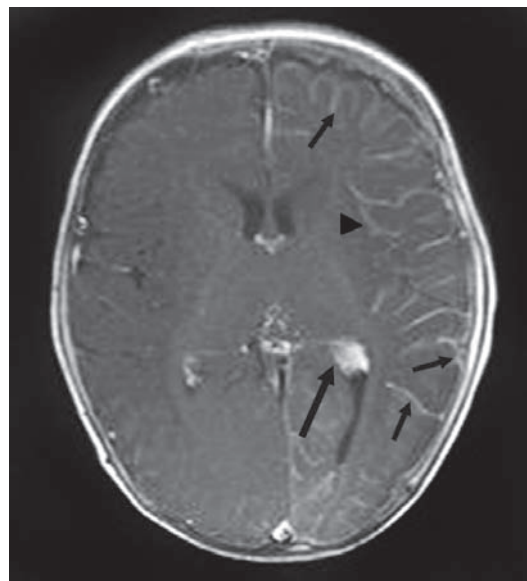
Sturge-Weber syndrome. Post-contrast axial T1 weighted MR image shows pial enhancement which follows the gyral and sulcal contours of the entire left cerebral hemisphere (arrowheads). The choroid plexus in the left lateral ventricle is enlarged (arrow)—another feature of the syndrome
